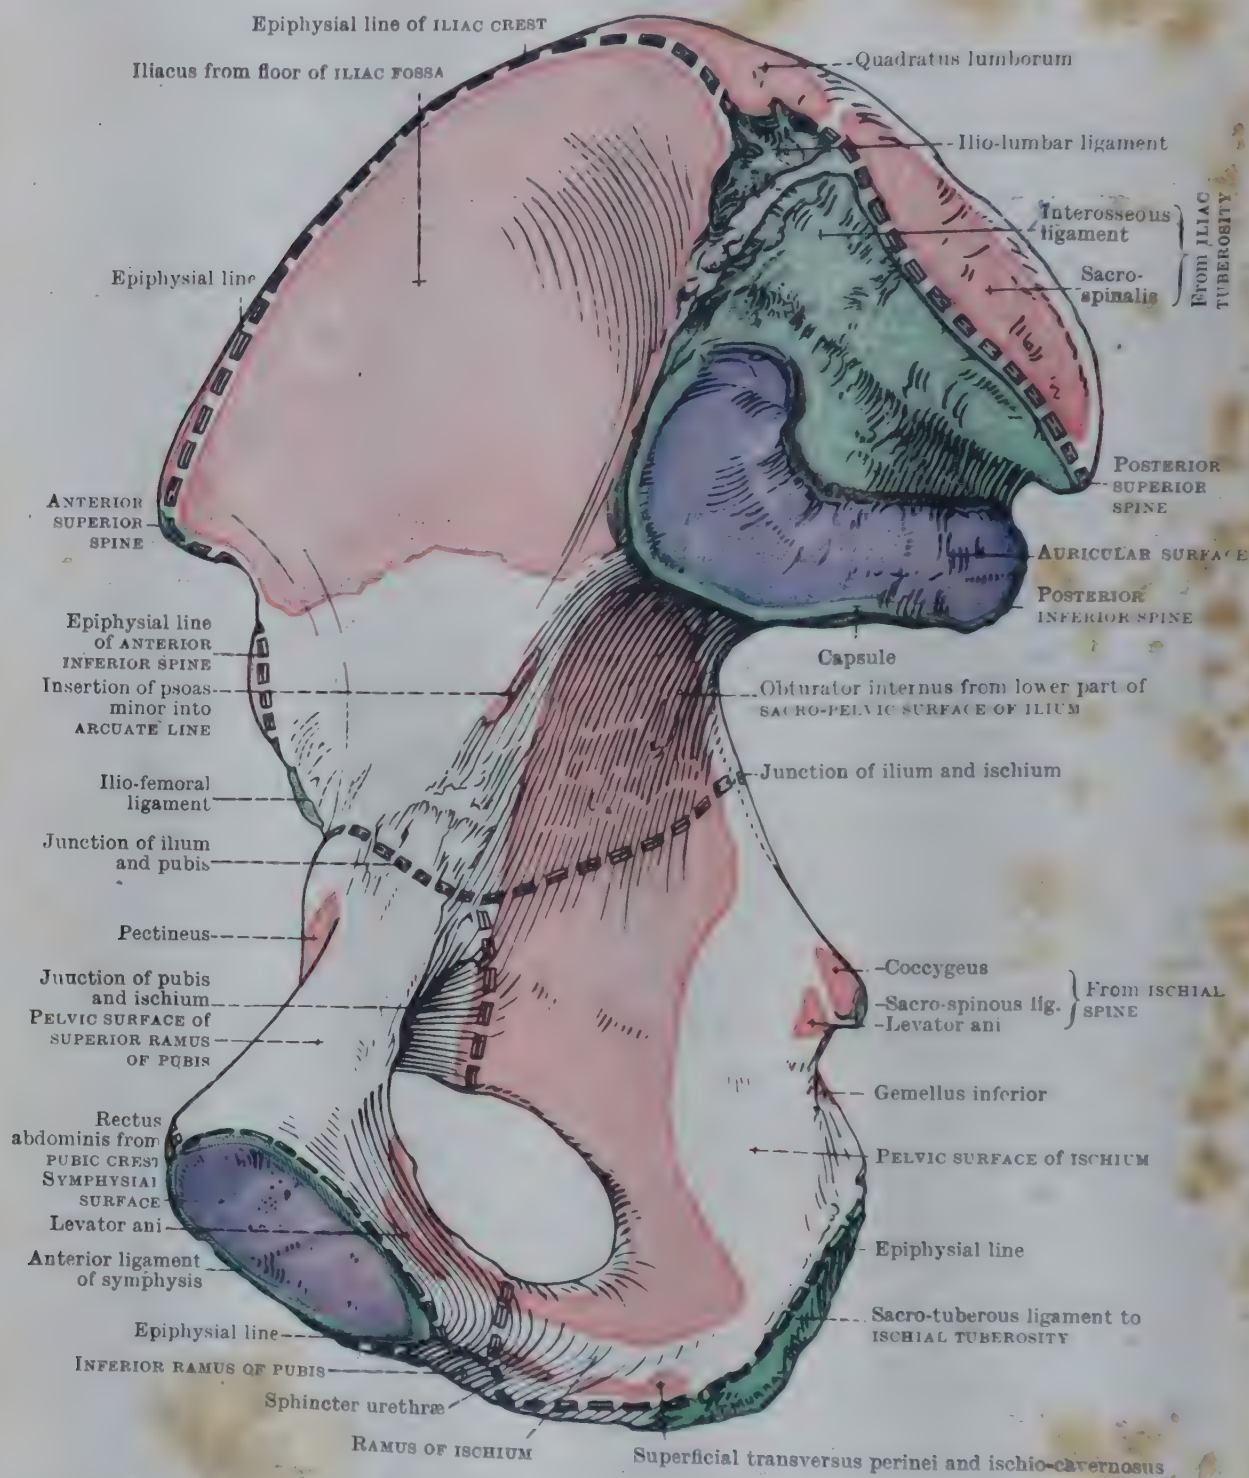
MEDIAL ASPECT OF RIGHT HIP-BONE.
